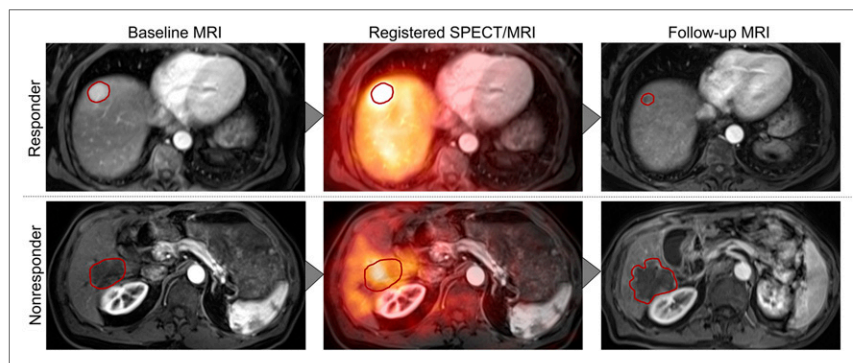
Multimodal image analysis. Postprocessing and analyses included volumetric segmentations of dominant tumors on baseline and follow-up MRI, registration of baseline MRI on postprocedural SPECT, and tumor response assessment.
